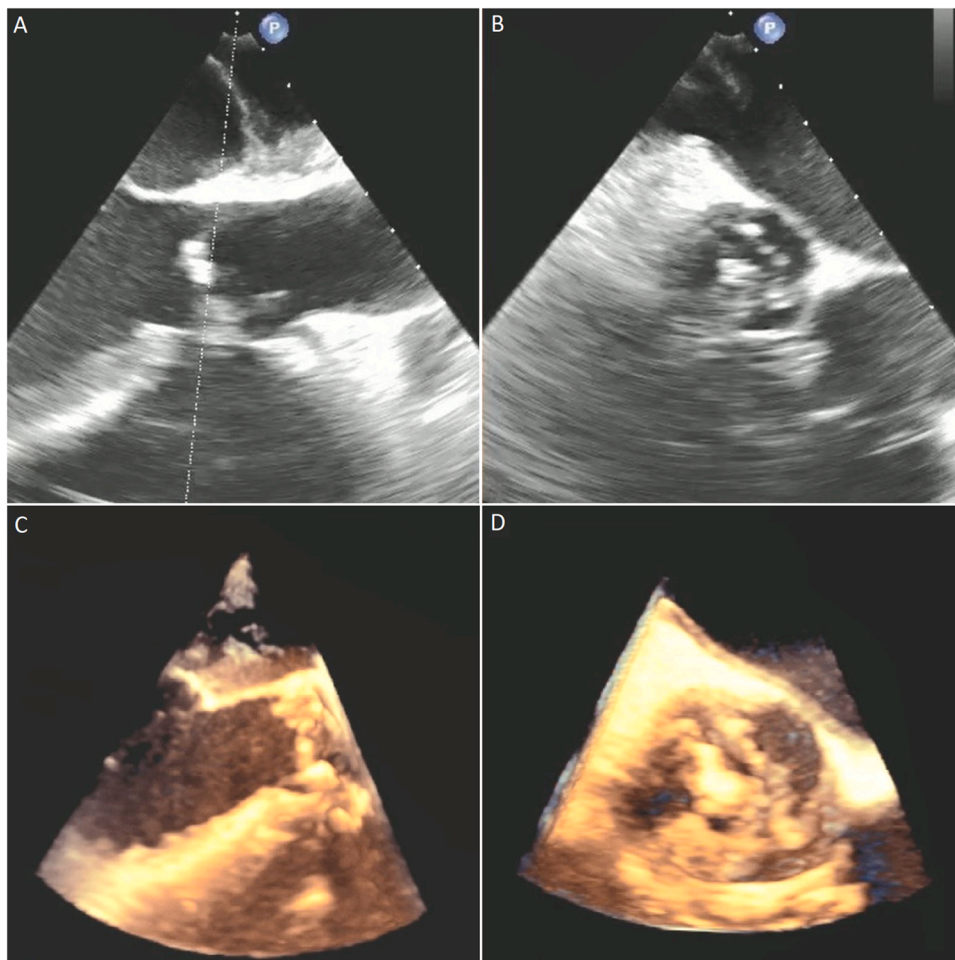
Transesophageal echocardiography (TEE) shows a long-axis (A) and short-axis (B) view of thickened aortic valve leaflets, along with 3D reconstruction (C and D).
